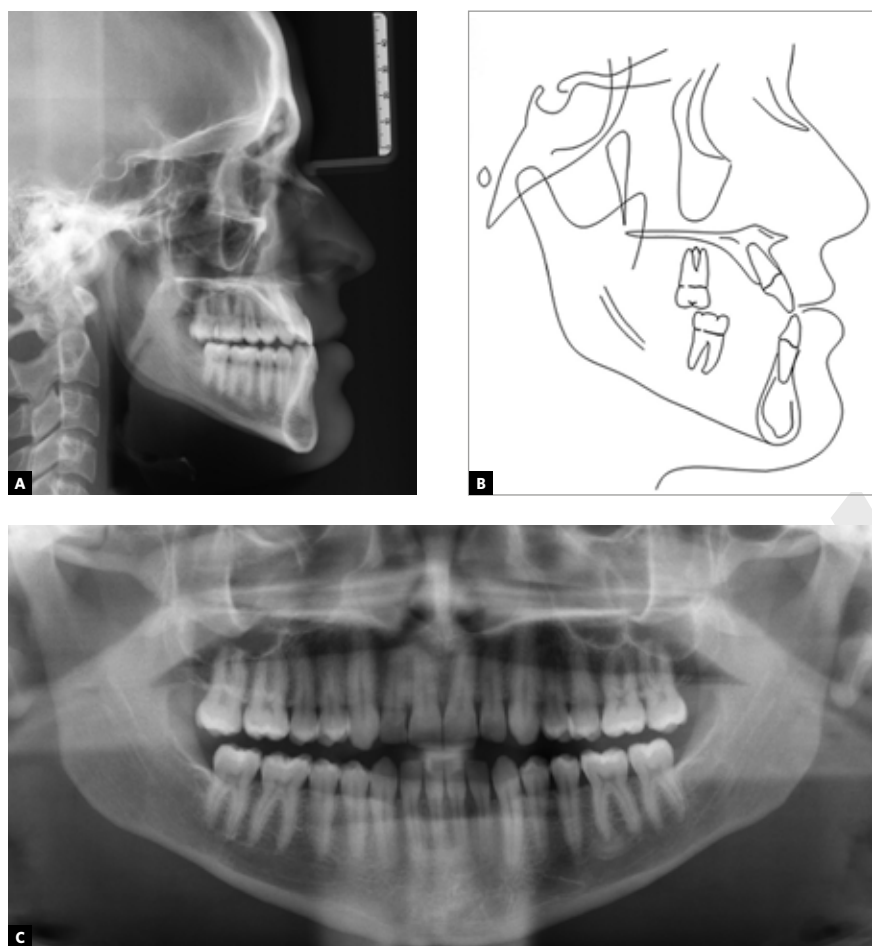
A) Pre-treatment lateral cephalometric radiograph; B) Pre-treatment panoramic radiograph. C) Pre-treatment lateral head film tracing.
